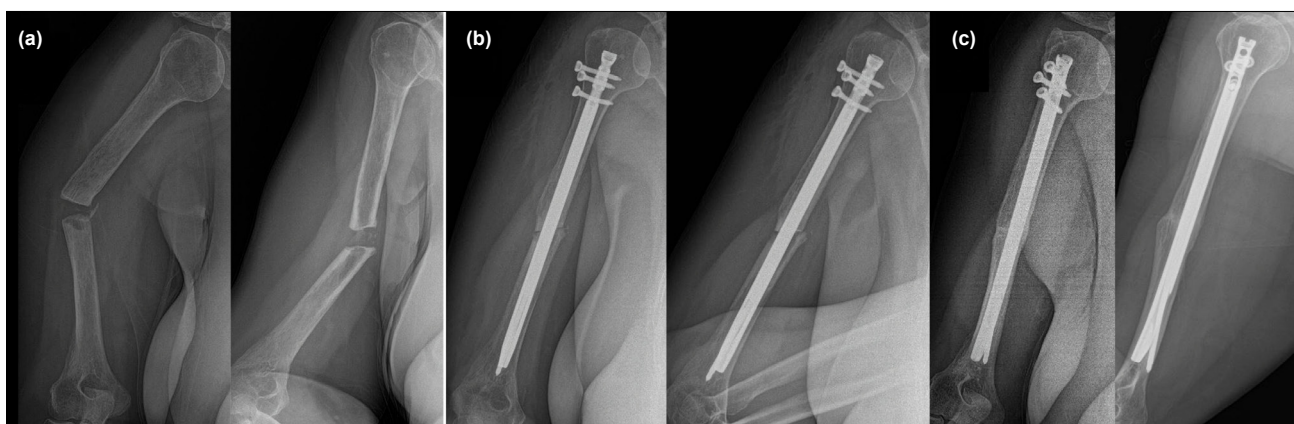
Closed reduction and compressive nailing were performed in a patient who underwent intramedullary nailing without grafting for nonunion 24 months after the initial fracture. Complete union was achieved. (a) Preoperative radiographs. (b) Early postoperative radiographs. (c) Radiographs at the second postoperative year.
